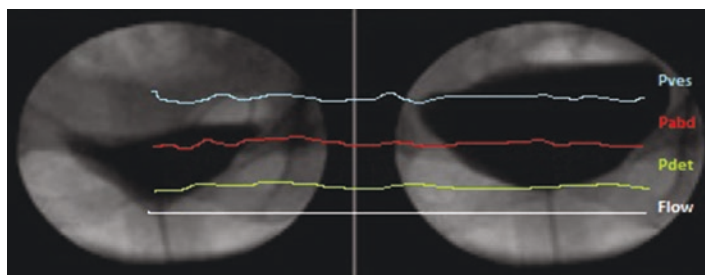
Videourodynamics. The bladder is filled with a radio-opaque contrast medium, with the simultaneous measurement of intravesical pressure and intra-abdominal pressure. The subtracted detrusor pressure is calculated automatically and flow is recorded with the flowmeter. Pressure measurements and accompanying radiographic pictures are mixed together allowing subsequent review and analysis
